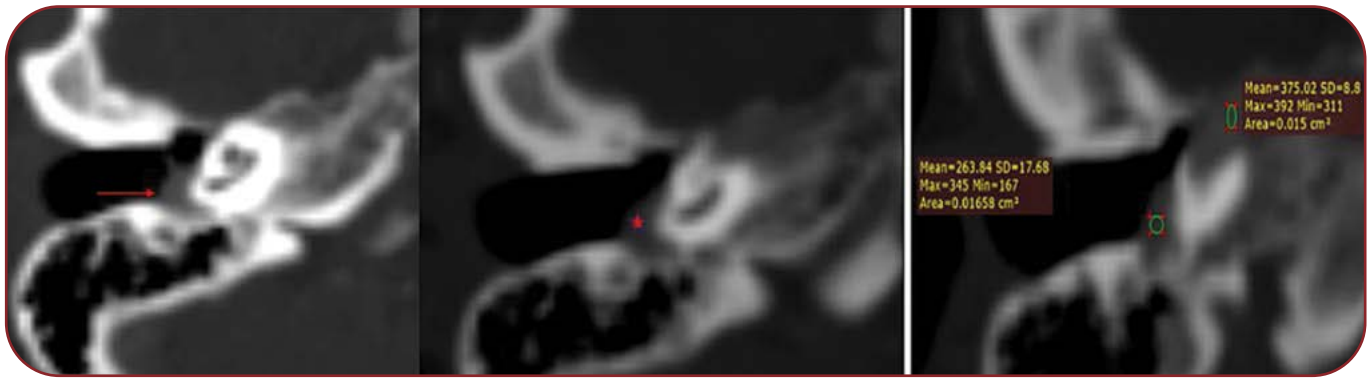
Case 3: tympanic paraganglioma. On high resolution computed tomography (HRCT) temporal bone axial images, an 8 mm lesion (red arrow and star) is seen in the region of the mesotympanum and hypotympanum overlying the cochlear promontory. On computed tomography (CT) angiography, the lesion shows avid enhancement (ROI).
